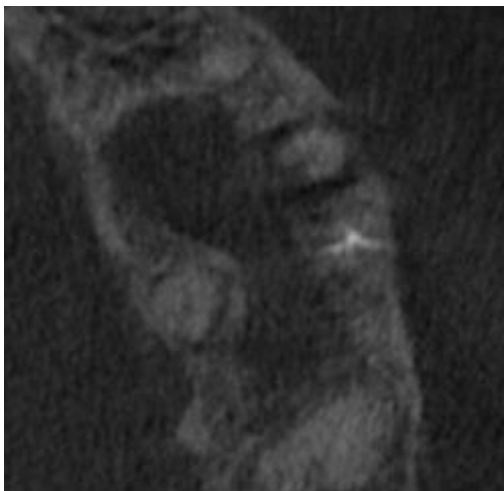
CBCT Axial View of #14
